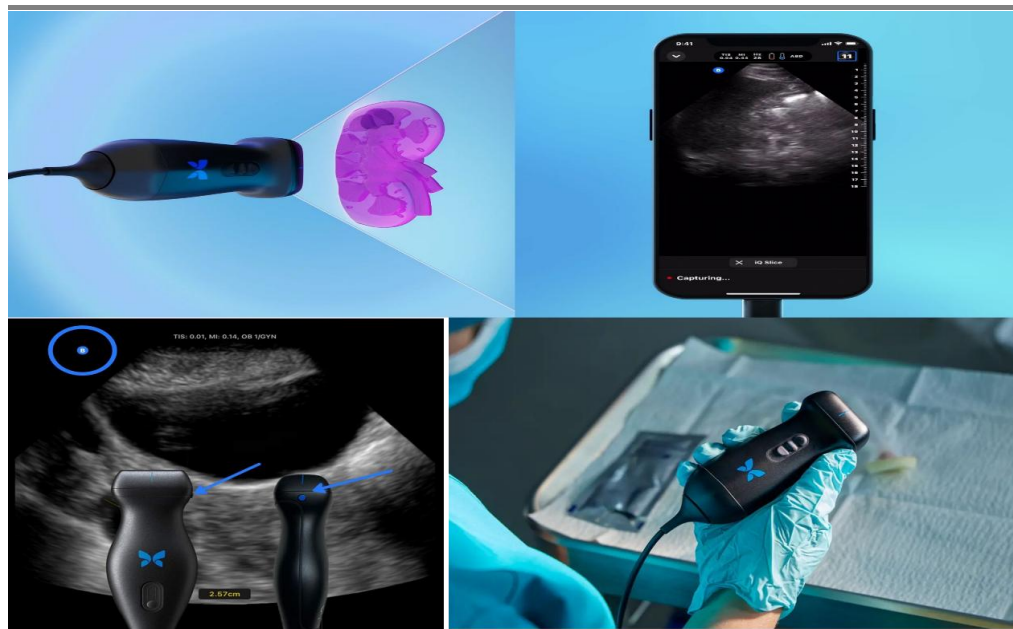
Butterfly Handheld Ultrasound - Used in the OIDvsNIO-NoAn project.
